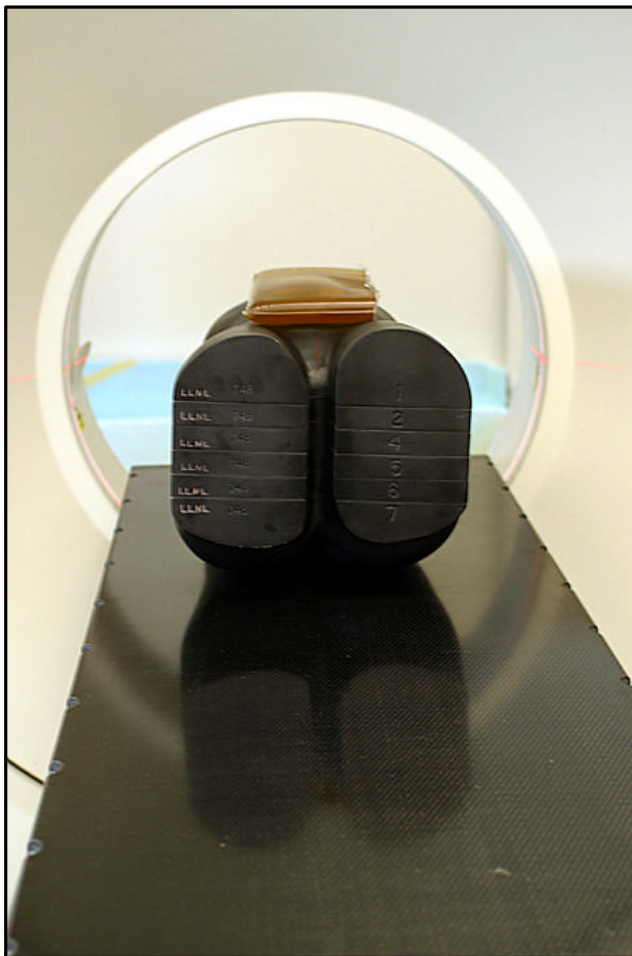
Photos of the RPHAT prototype at the CT scanner with bolus material
